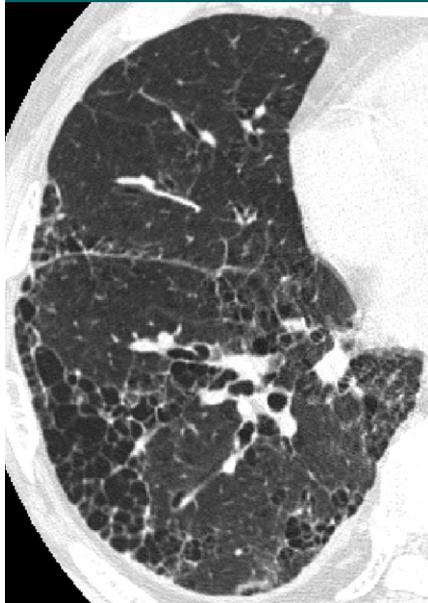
UIP pattern in a 69-year-old man. Transverse thin-section (1-mm) CT image through the right lower lobe shows broad honeycombing in a predominantly peripheral distribution. Pathologic diagnosis of UIP was made.
